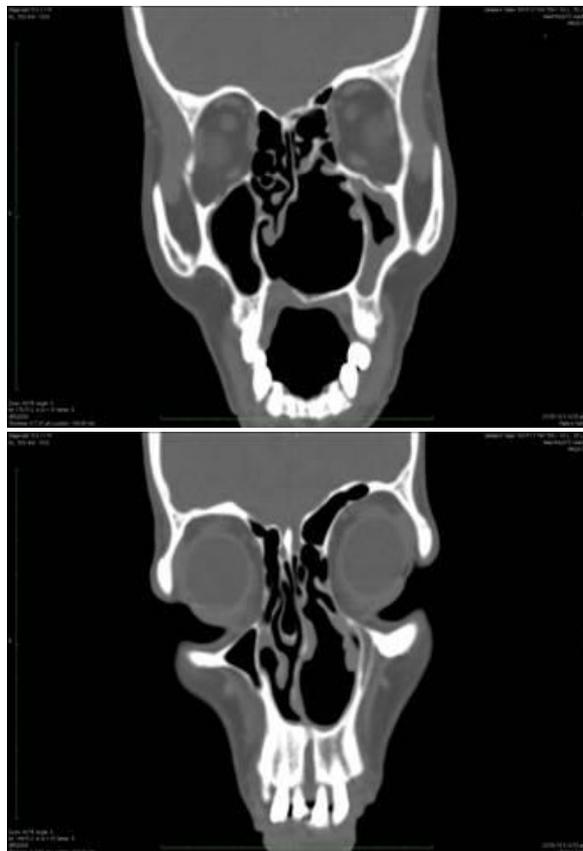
CT Scan showing perforation in hard palate and calcified foreign body in nasopharynx.
